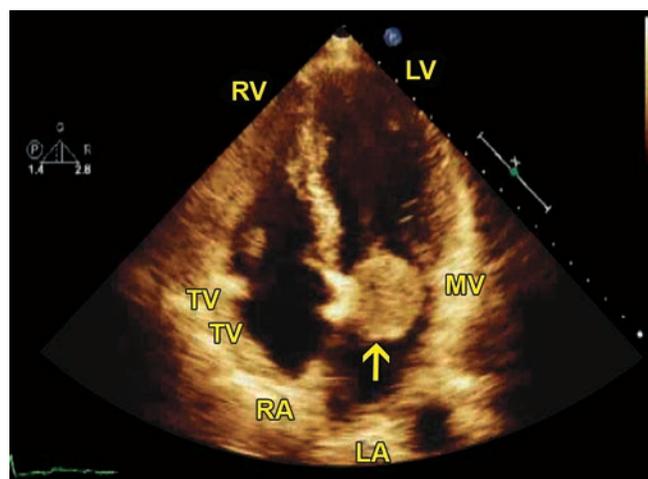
TTE. Apical 4 chamber view. The mass (arrow) is attached to the atrial septum.
